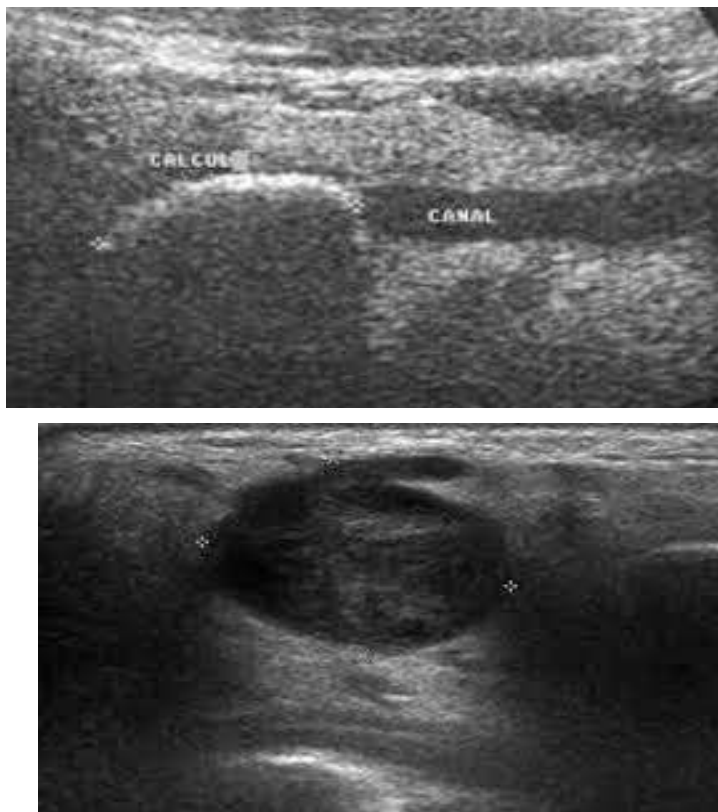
Cervical ultrasound revealing a fluid collection in the left submandibular gland suspicious
